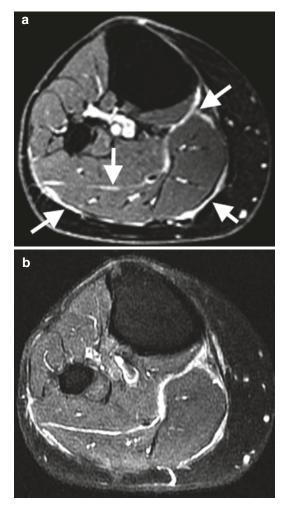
Eosinophilic fasciitis on MRI, (a) axial T2FS calf demonstrating high SI thickened fascia (*arrows*) and (b) with marked enhancement on axial T1FS post-gadolinium
